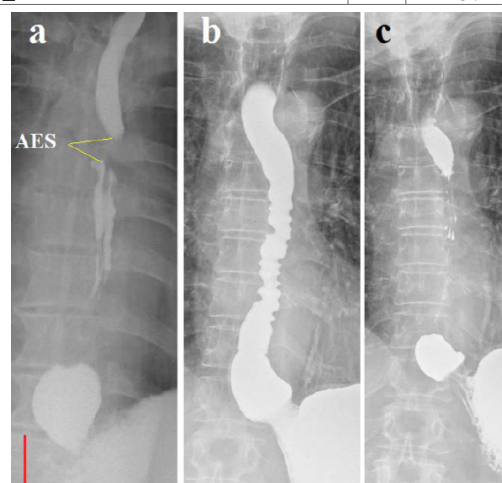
Case 6 (a). Radiograph recorded the moment of contraction of the PS, resulting in the contracting ampulla could create a pressure for opening the LES, which was higher than the pressure in the stomach. This allows the ampulla to inject a bolus into the stomach. The true length of contraction of the AES at the level of D5-6 is 0.7 cm.
